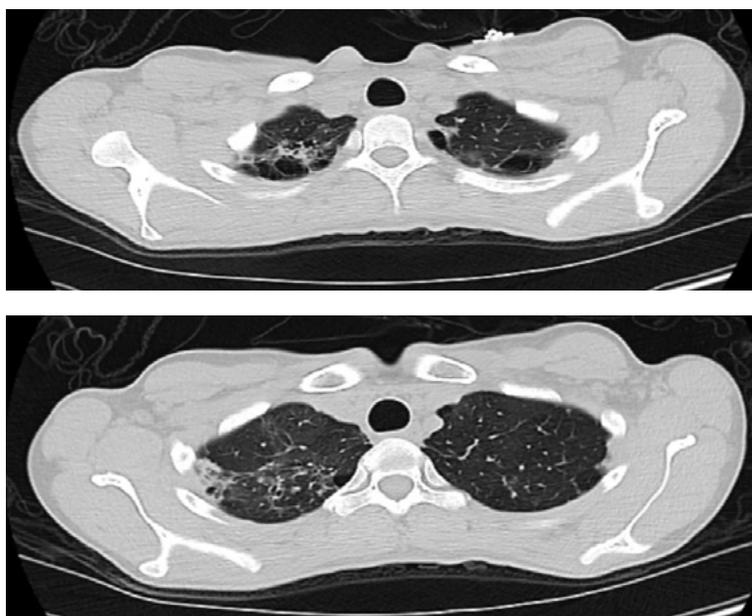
CT scan shows reticular opacities bilaterally more in the right apex involving the pleura and mild traction bronchiectasis.
